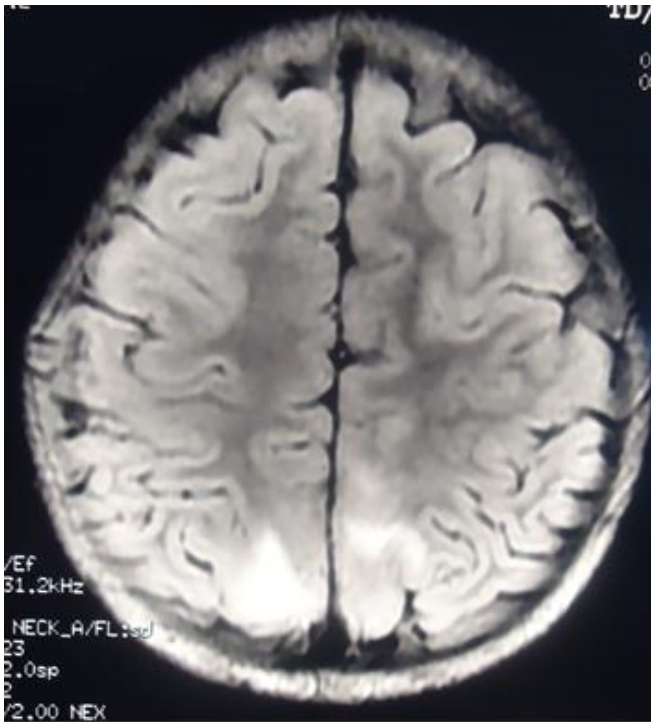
MRI brain showing bilateral areas of abnormal signal intensity in cortical and subcortical areas of the parieto-occipital region, which is hyperintense on T2 weighted image.
